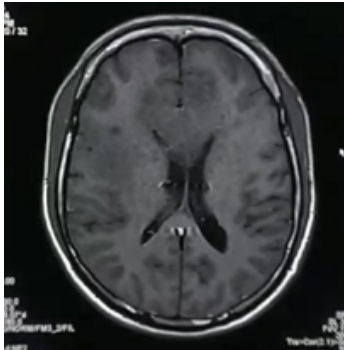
(T1 contrast MRI)
